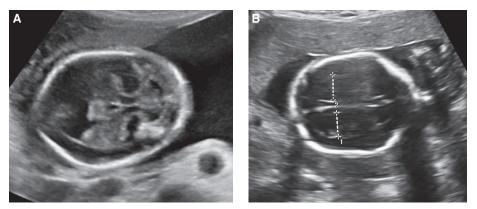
Intracranial ultrasound findings in fetuses with open NTDs: banana sign (A), lemon sign (B).
